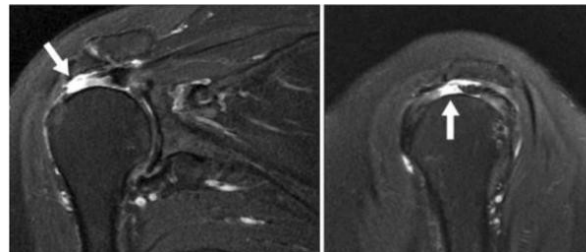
shows full thickness tear at right supraspinatus tendon (arrow) in coronal and sagittal planes of fat saturated T2-weighted MR images in Hypertensive patient
